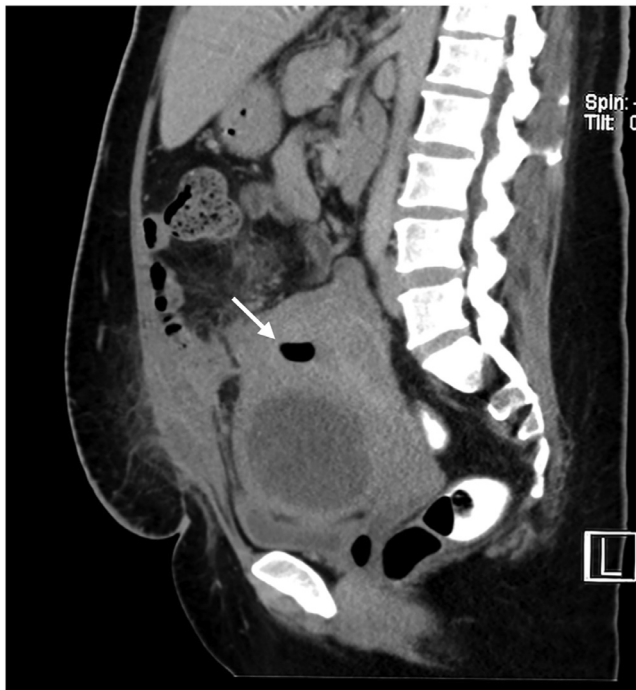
Sagittal reformatted contrasted CT abdomen revealed mild hydrometra and air locules (white arrow) within the uterine cavity. Additionally, there is a rim-enhancing collection along the anterior uterine body, along with intramuscular collections within the rectus abdominis muscles and subcutaneous fat stranding, suggestive of an active infection.
